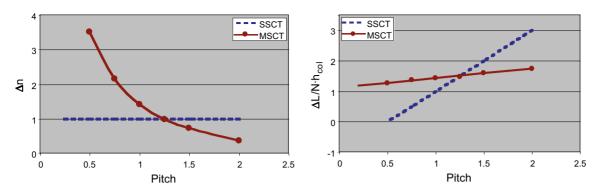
While single-slice computed tomography scanners (SSCTs) usually require only one additional rotation Δn in spiral scanning mode, multi-slice computed tomography scanners (MSCTs) show a pronounced pitch dependence. Conversely, the normalized elongation of the scan range, $\Delta L/N \cdot h_{col}$, is almost constant for most MSCT scanners, but increases linearly with pitch for SSCT scanners
